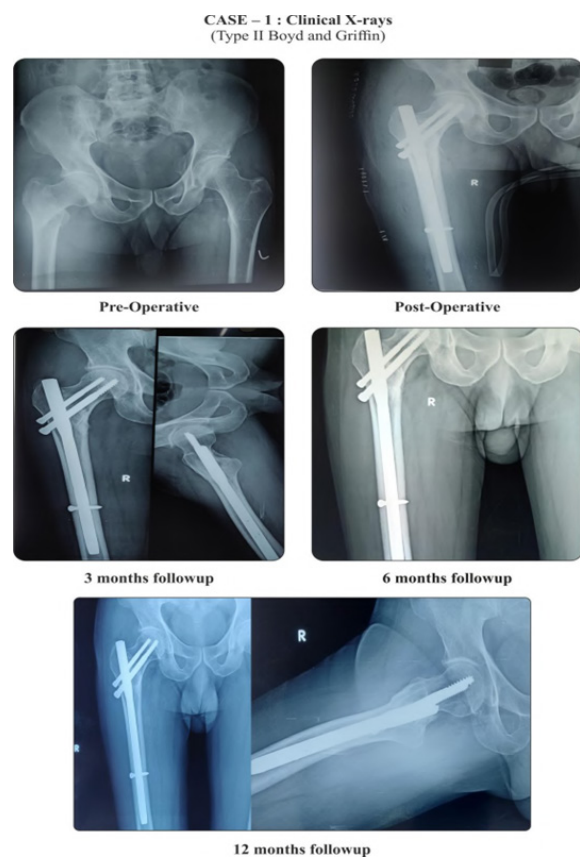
Plain radiograph of right hip anteroposterior and lateral view showing Pre-operative, post-operative and follow up images at 3,6 and 12 months respectively.
